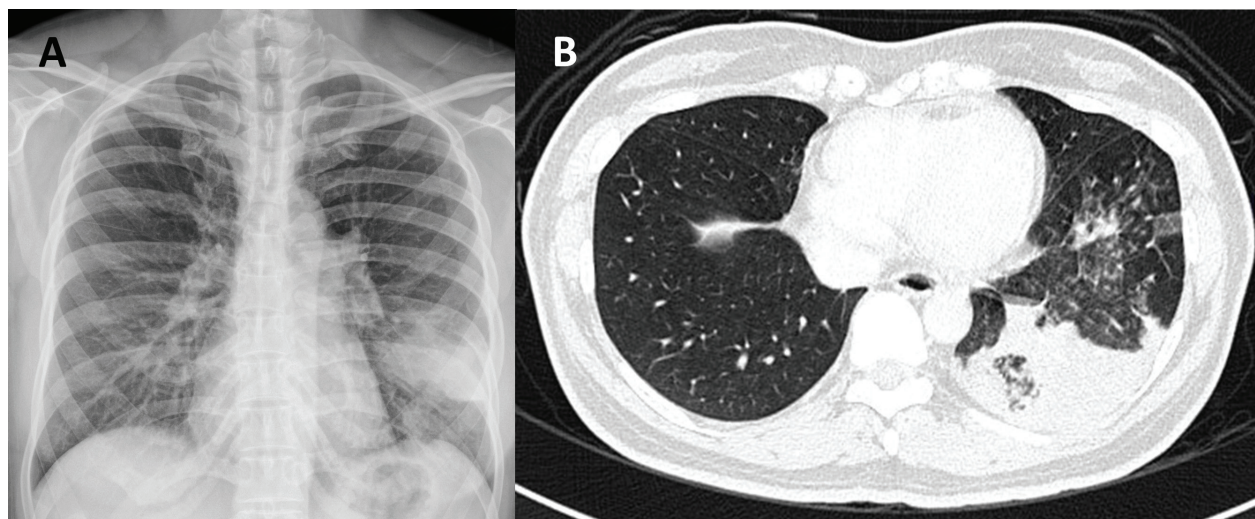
(A) 10 days prior to admission in Hospital A, chest X-ray showed infiltrates in the left lower lung field. (B) On admission, atelectasis and consolidation were seen in the left lower lobe on chest CT scan.
